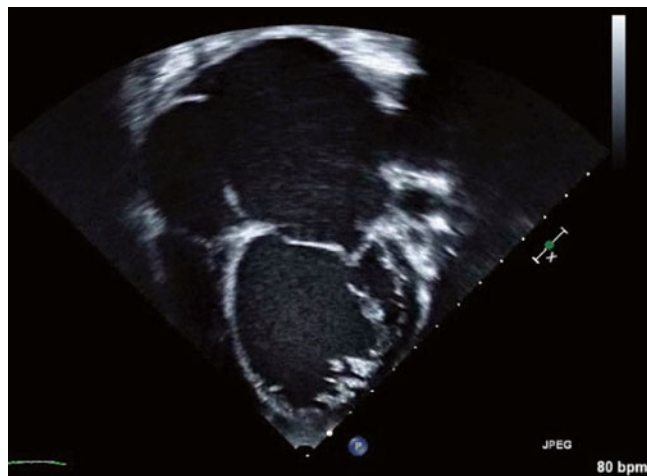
Representative echocardiogram in DCM
